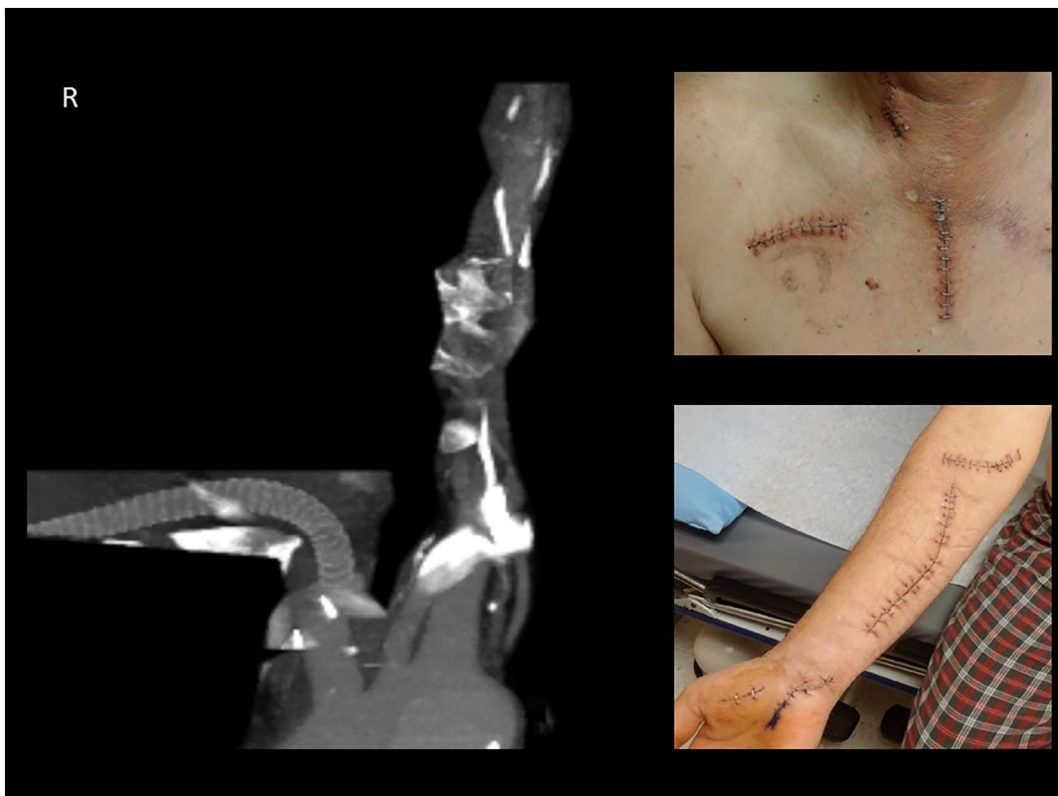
Post-operative CTA reconstruction showing patent graft (left panel) and incision sites (right: top and bottom panels).
